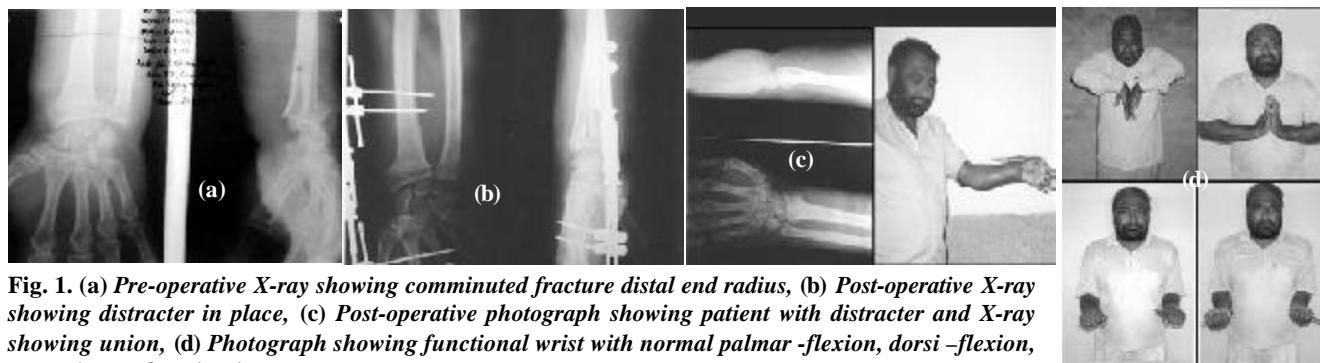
(a) Pre-operative X-ray showing comminuted fracture distal end radius, (b) Post-operative X-ray showing distracter in place, (c) Post-operative photograph showing patient with distracter and X-ray showing union, (d) Photograph showing functional wrist with normal palmar-flexion, dorsi-flexion, pronation and supination
